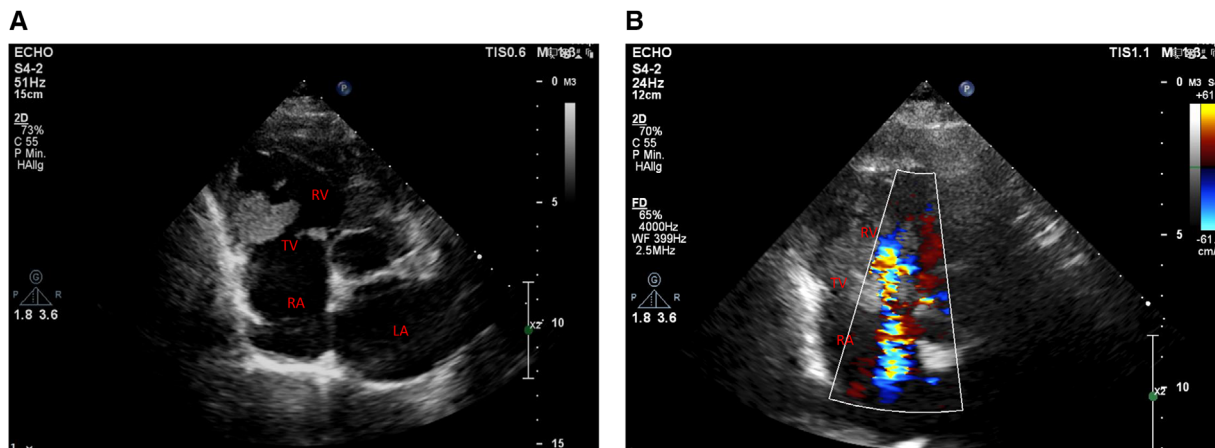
(A) Bedside two-dimensional transthoracic echocardiography. Parasternal short-axis view showing a large masse adhering to the tricuspid valve. TV, tricuspid valve; RA, Right atrium; RV, Right ventricle; LA, Left atrium. (B) Color doppler echocardiography reflecting tricuspid insufficiency which was estimated as non-severe by the given limited quality of the imaging in the point-of care setting
